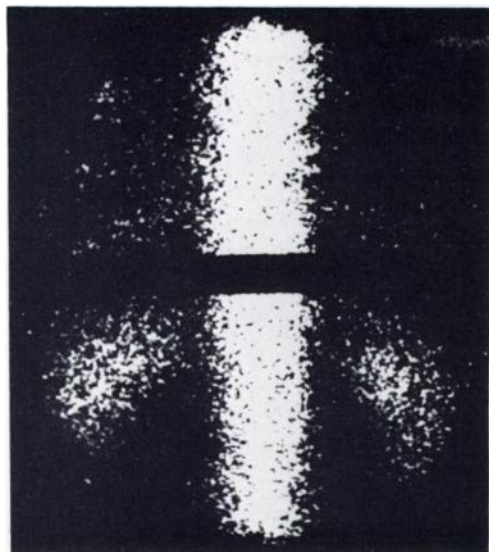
Control study: scintigram of lower dorsal and lumbar spine. Horizontal strip shows region of interest for activity profile.
